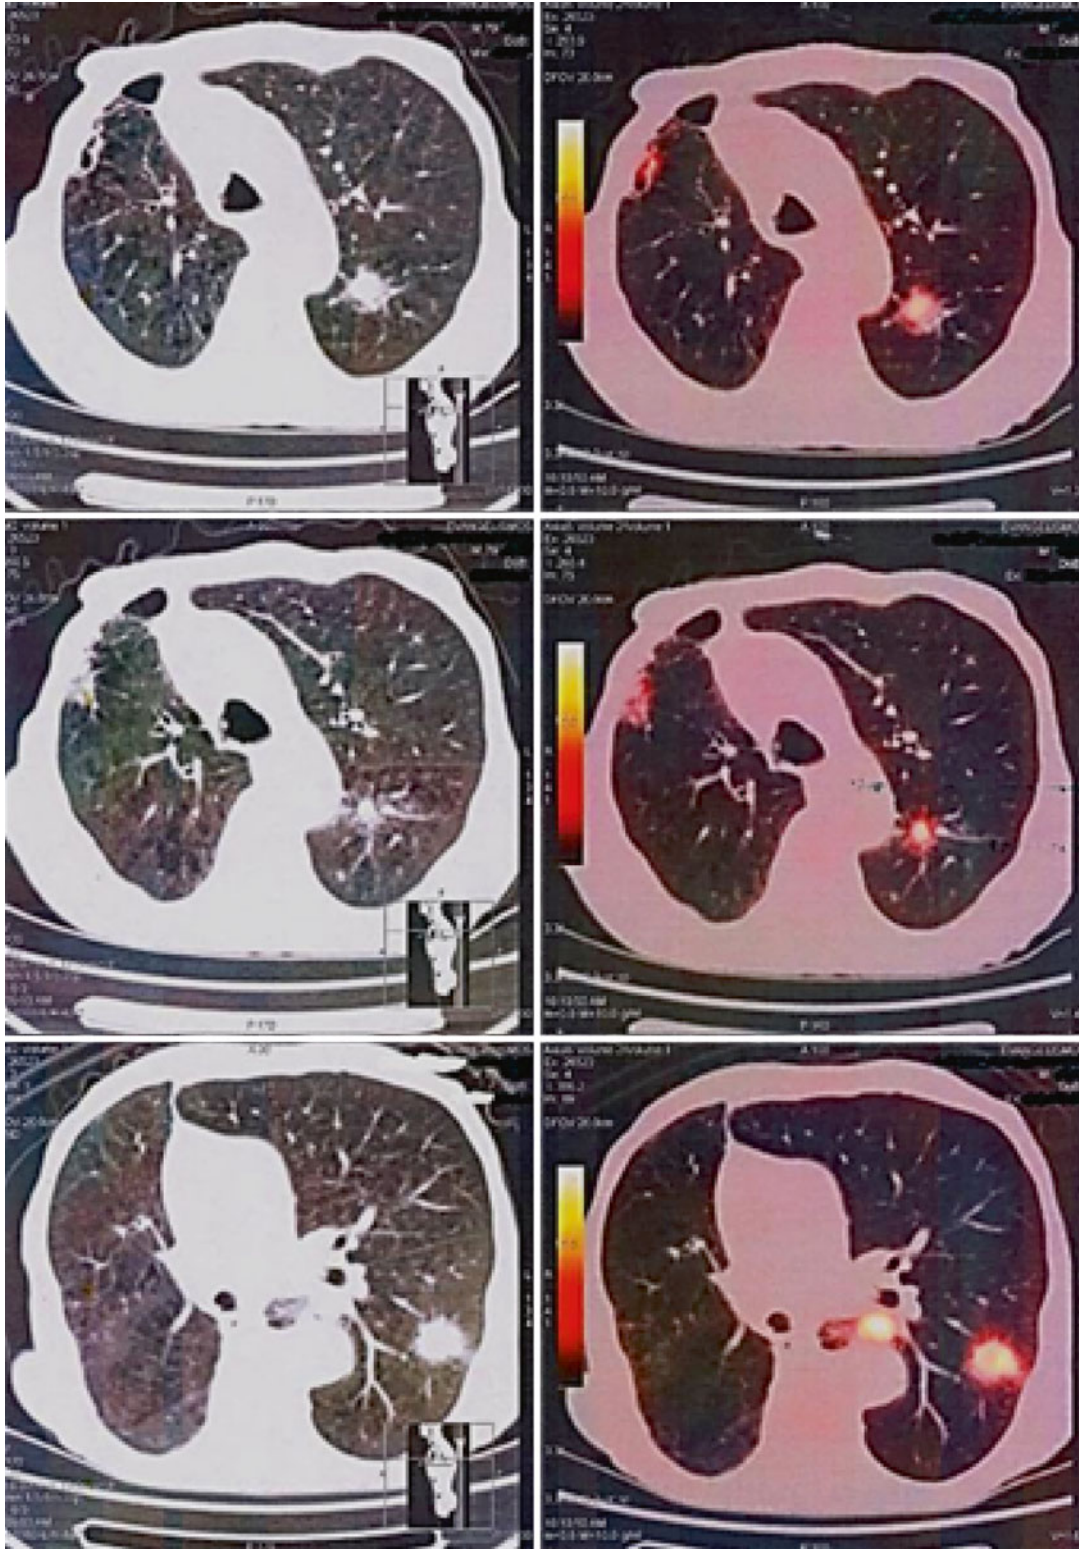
Axial CT and corresponding axial fused PET/CT images of the chest reveal multiple nodular FDG-avid lesions in both lungs
